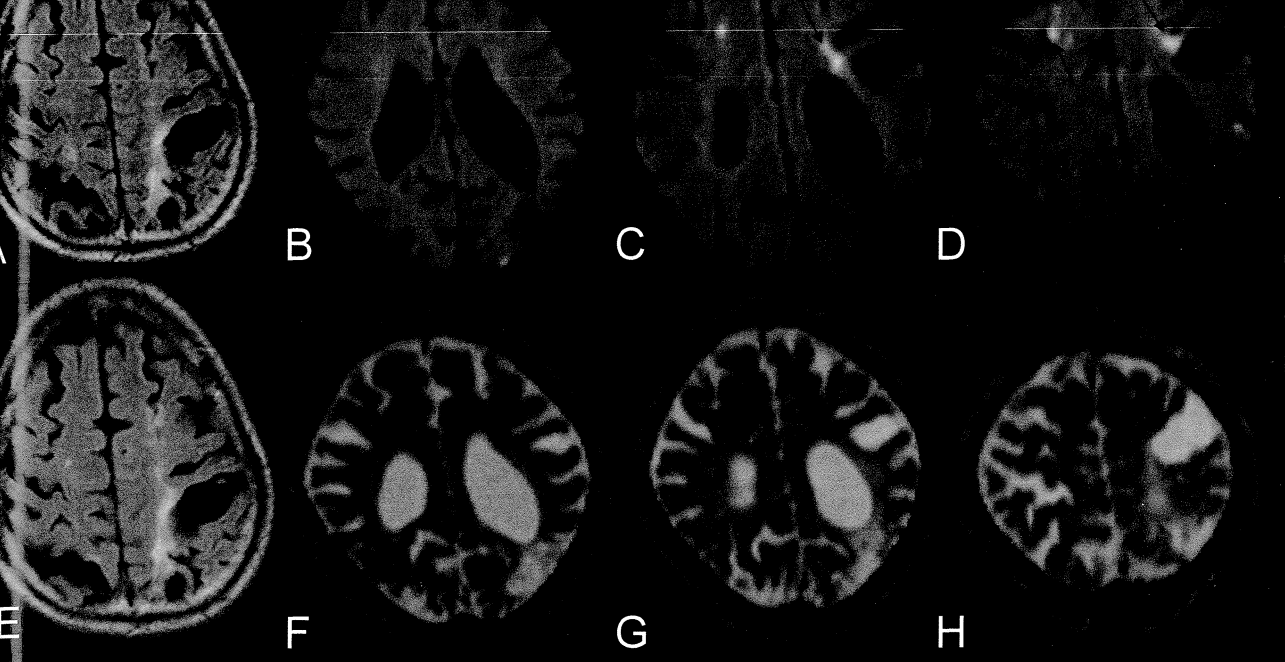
Patient with left ICA stenosis. A and E, FLAIR images pre and postprocedure. B and F preprocedure DWI and ADC maps. C, D, G and H post procedure DWI and ADC maps. Patient was asymptomatic following left carotid stenting, but DWI images showed silent ischemic foci on both right and left sides (C and D). These foci were not seen on postprocedure FLAIR images.
